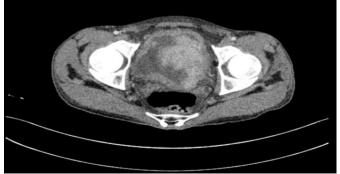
Computed tomography scan showing a large tumor of the urinary bladder
